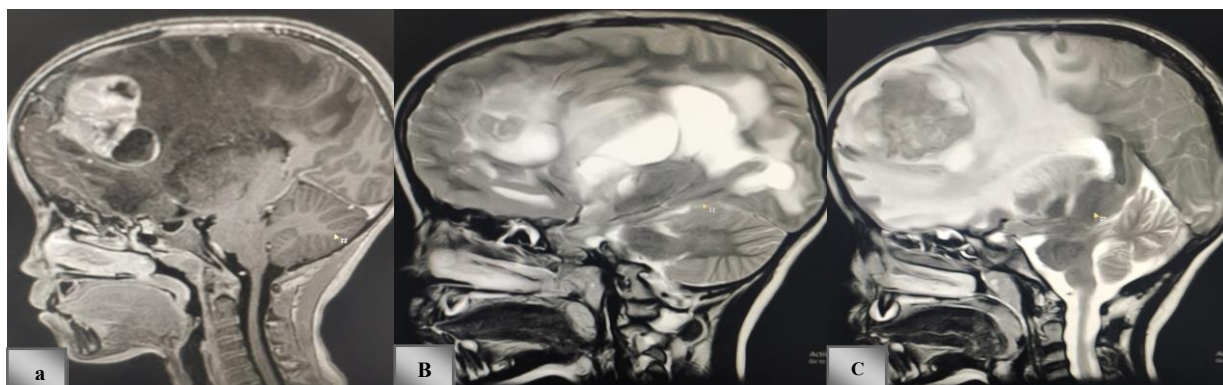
Preoperative contrasted Brain MRI (sagittal cuts) show a large heterogenous mass within the right frontal lobe (A) with extensive edema around the mass, (hyperintense in T2 (B&C))
